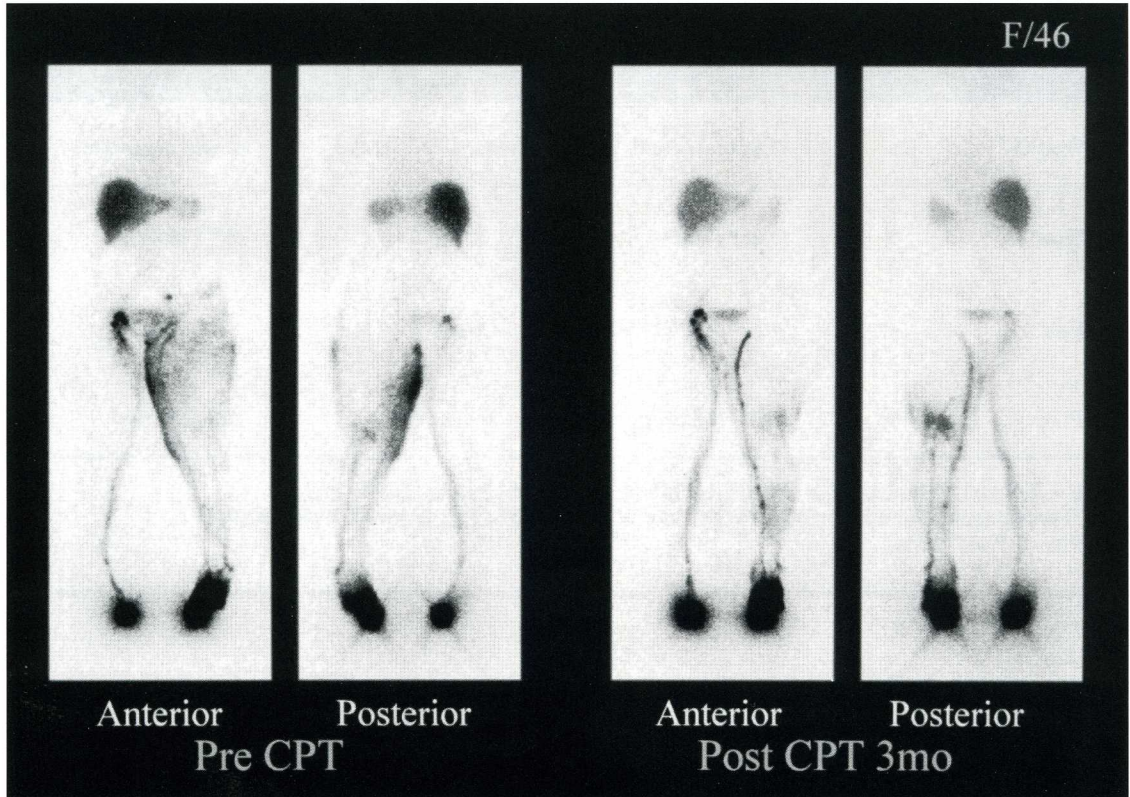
Lymphoscintigraphy of 46-year old woman with post-hysterectomy lymphedema before and after CPT. Decreased dermal backflow and increased radiotracer uptake of left main lymphatic vessels are seen.
